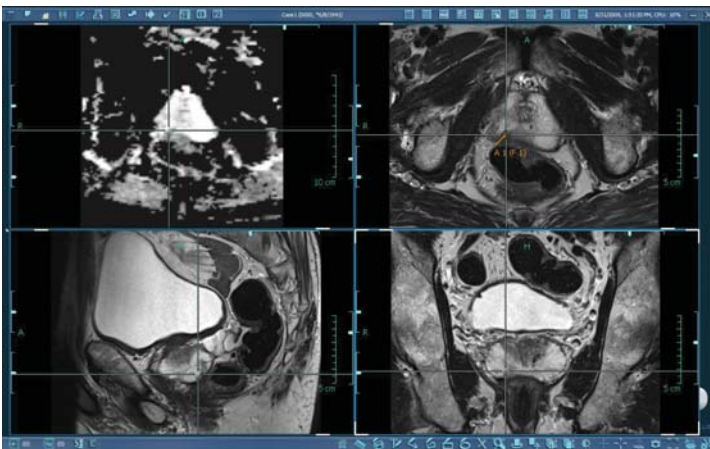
Multi-planar T2-weighted images and ADC map
